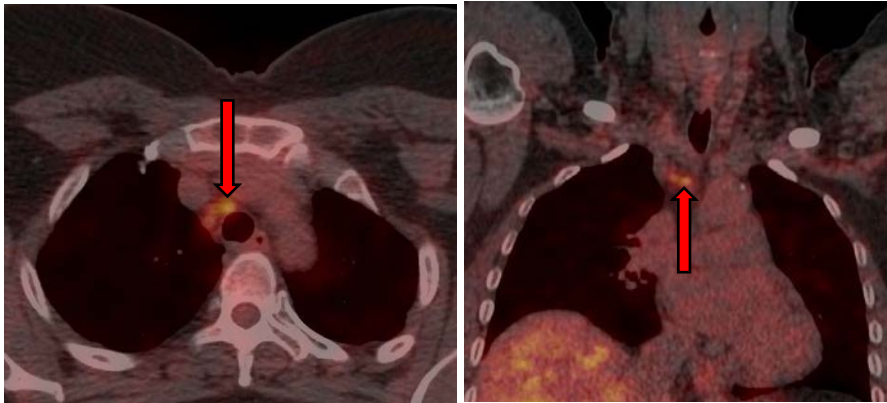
A 55-year-old with luminal disease with a station 2 mediastinal lymph node suspicious for metastasis on FDG PET/CT. Subjected to endobronchial ultrasound guided biopsy. SUV_{max} breast primary 8.4 node 3.4. Biopsy results were negative for malignancy.
